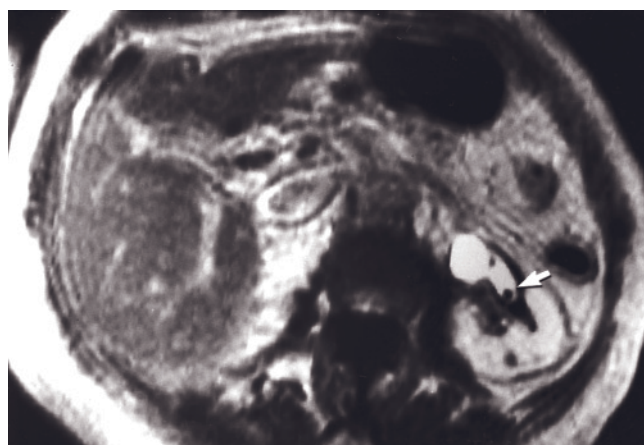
Renal calculi. T1-weighted precontrast SGE (a), T2-weighted SE (b), and T1-weighted 10-min fat-suppressed postgadolinium SE (c) images. The renal calculus in the right renal pelvis is signal void on all sequences (a-c). Conspicuity of the calculus
